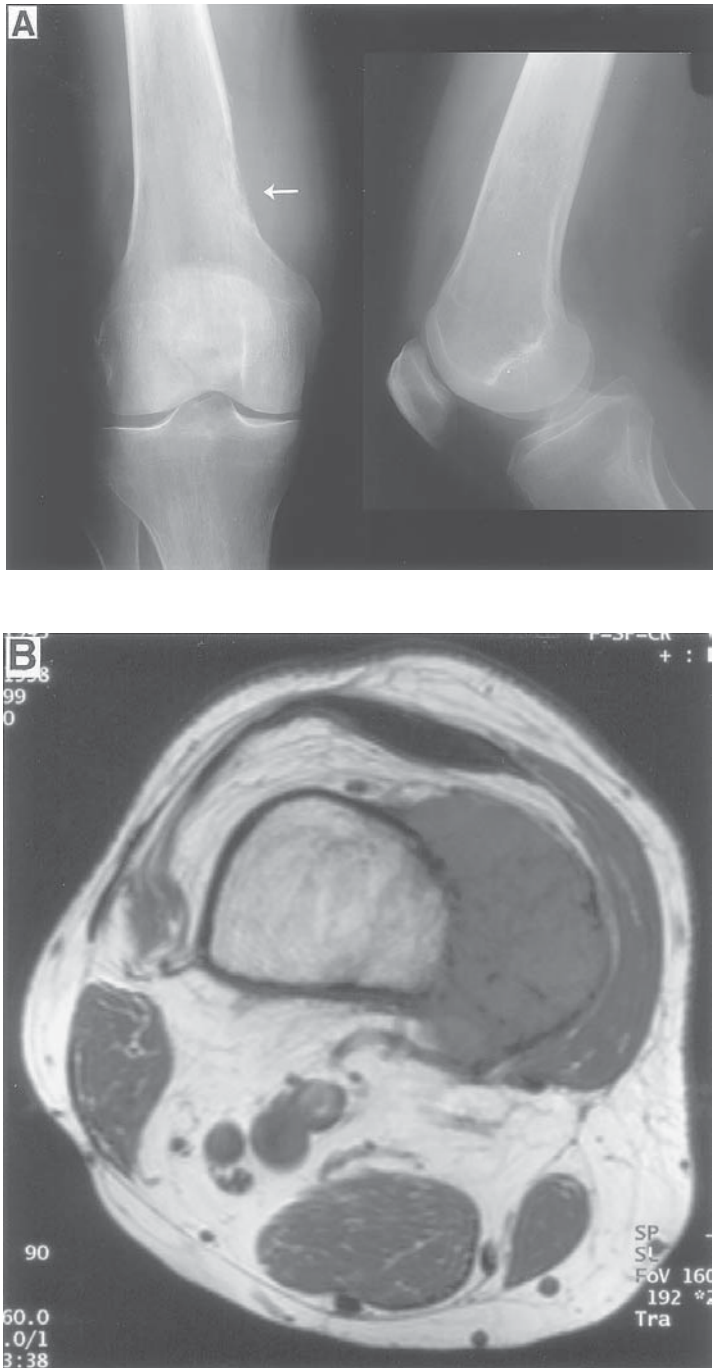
(A) A 57-year old male with distal thigh pain. Radiographs show violation of the distal medial cortex. (B) MRI shows a huge external soft tissue mass on the medial side with little intra-medullary involvement.
